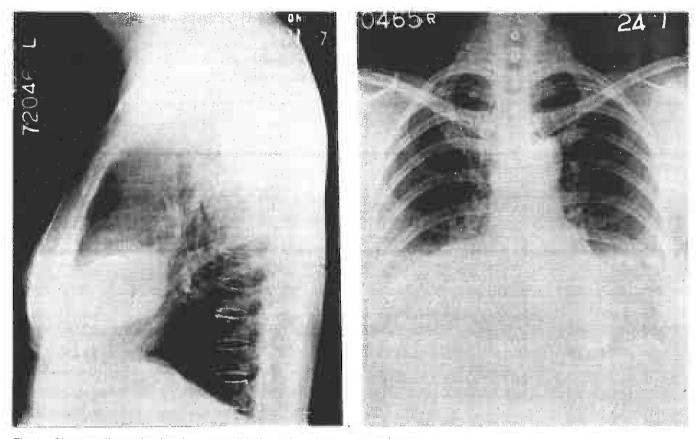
Chest radiograph showing consolidation of middle lobe and lingula.
